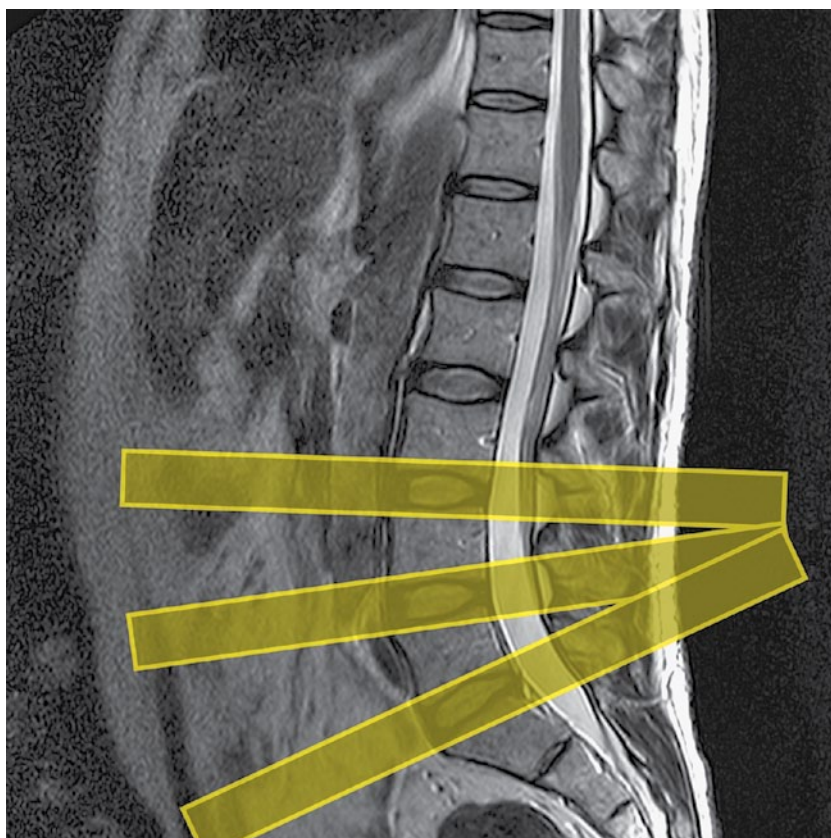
Sagittal FSE T2-weighted midline slice through the lumbar spine showing normal appearances.
